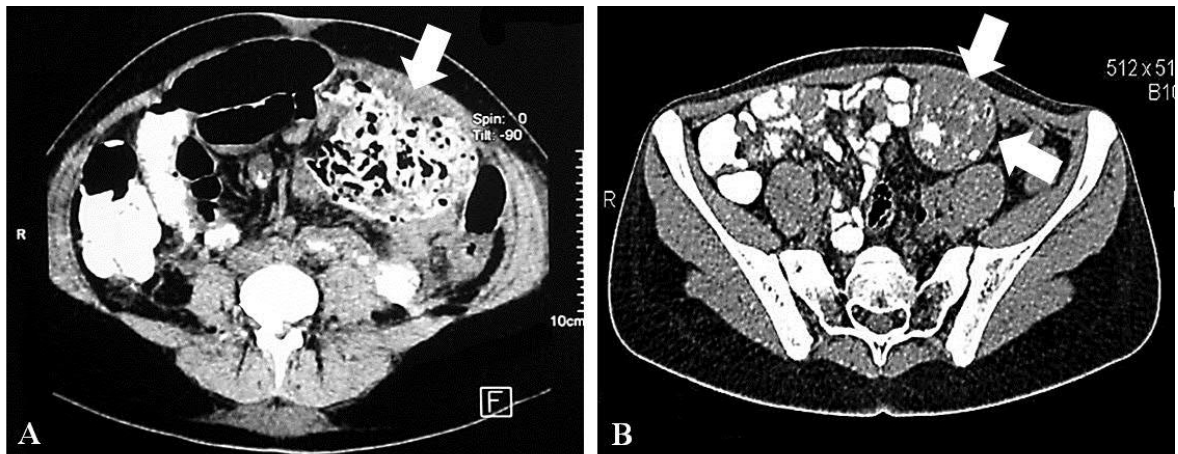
Acute and chronic types of abdominal textiloma on CT
